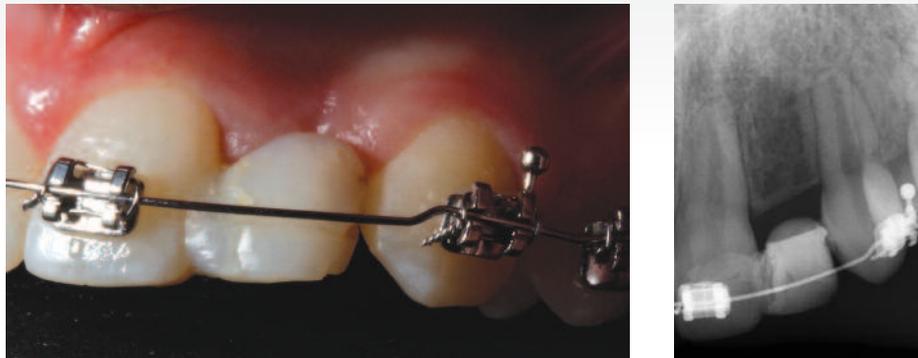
Orthodontic intervention, uprighting 21/23, picture and radiograph.
